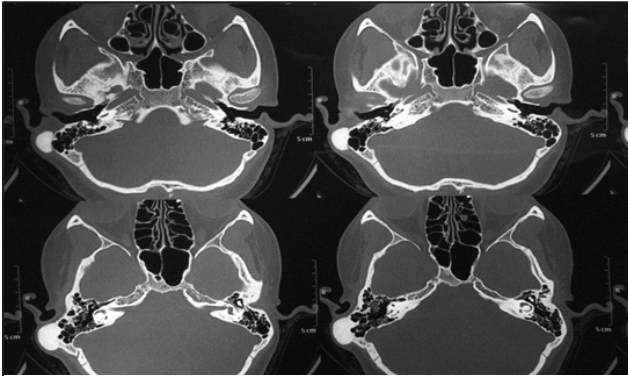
II CT- scan depicting a pedunculated dense osteoma arising from outer cortex of the right mastoid
